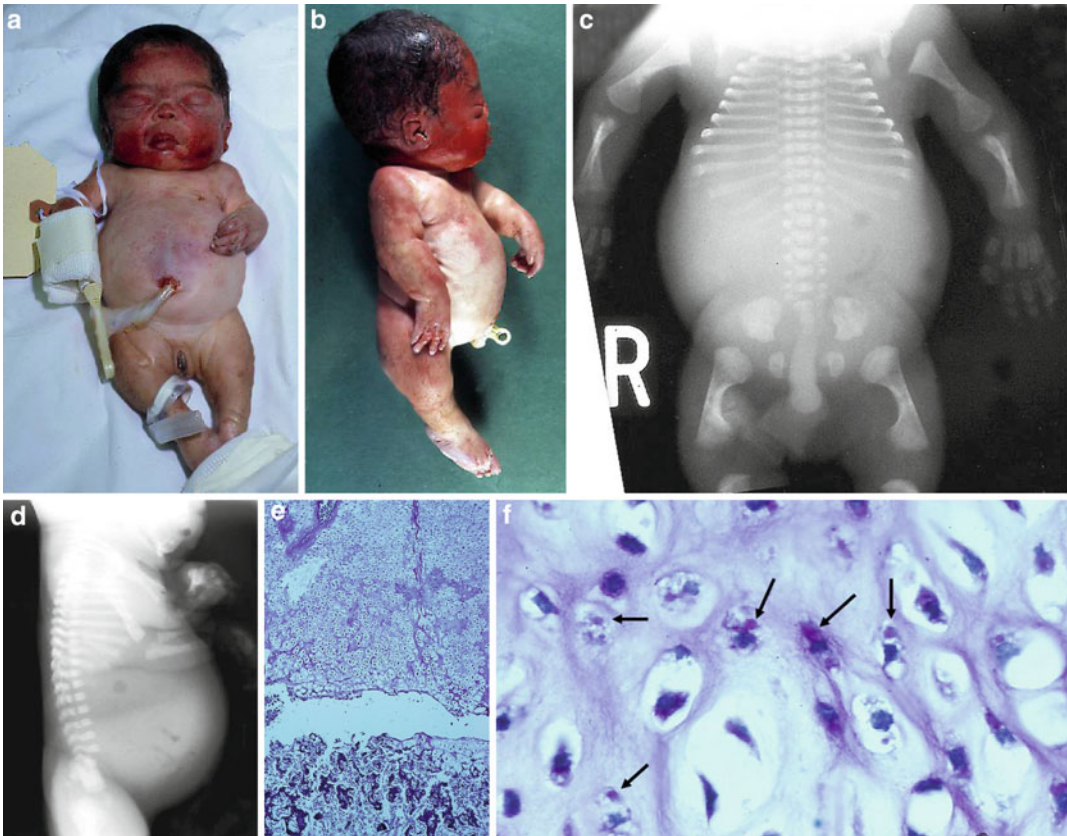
(a–f) A neonate with Kniest dysplasia showing short trunk and large head, similar to SED congenita. However, the moderately shortened limbs show prominent joints (a, b). Radiographs show enlarged metaphyses of limb bones (dumbbell-shaped femora) and coronal clefts of the vertebrae (c, d). The remaining findings are similar to
